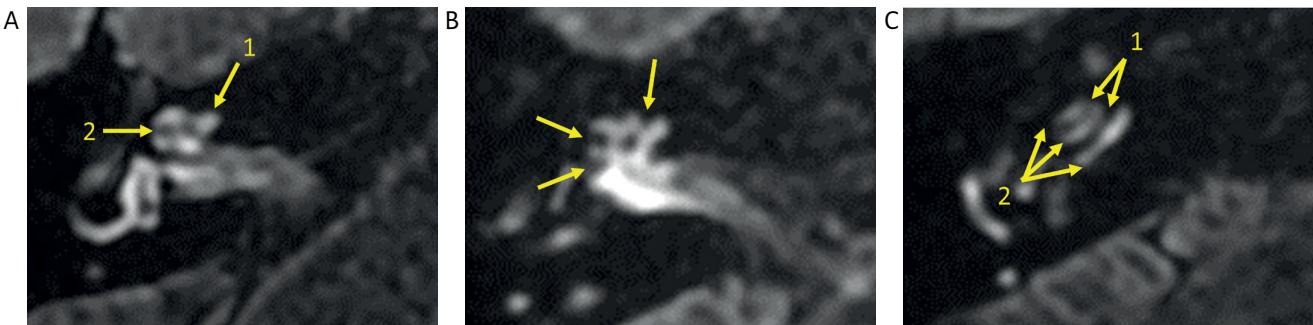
MRI of the inner ear – a 3D-FLAIR T2-weighted sequence performed 4 hours after intravenous administration of a double dose of the contrast agent – assessment of the cochlear hydrops grade, according to Barath et al. [22] and Bernaerts et al. [23]. (A) The typical image of the cochlea without enlargement of endolymphatic spaces – arrow #1 points to contrast-enhanced scala vestibuli and scala tympani, arrow #2 points to the osseous spiral lamina and the narrow cochlear duct visible as a slight defect in contrast enhancement; (B) grade I cochlear hydrops – arrows point to partial enlargement of the cochlear duct, obstruction of scala vestibuli is also visible; (C) grade II cochlear hydrops – arrows #1 point to the cochlear hydrops, significantly enlarged along the entire length and extending into the scala vestibuli area; arrows #2 point to the contrast-enhanced scala tympani.
